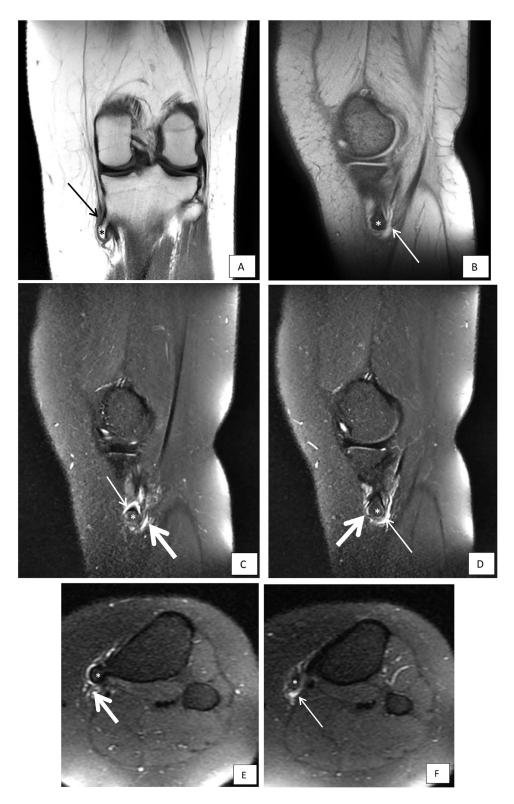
(A-F) – MRI of the knee, in coronal T1 (A), sagittal MERGE (B), and sagittal (C, D) and axial DP FATSAT (E, F), showing a bony mass (*) arising from the tibia proximal metaphysis, measuring $10\times8\times13$ mm, with a thin cartilaginous cap (2 mm). We also found fluid (white arrow on C, D, F) beneath the tendons of the pes anserinus at the medial aspect of the tibia associated with surrounding tissue edema (large arrow on C, D, E): anserine bursitis.
